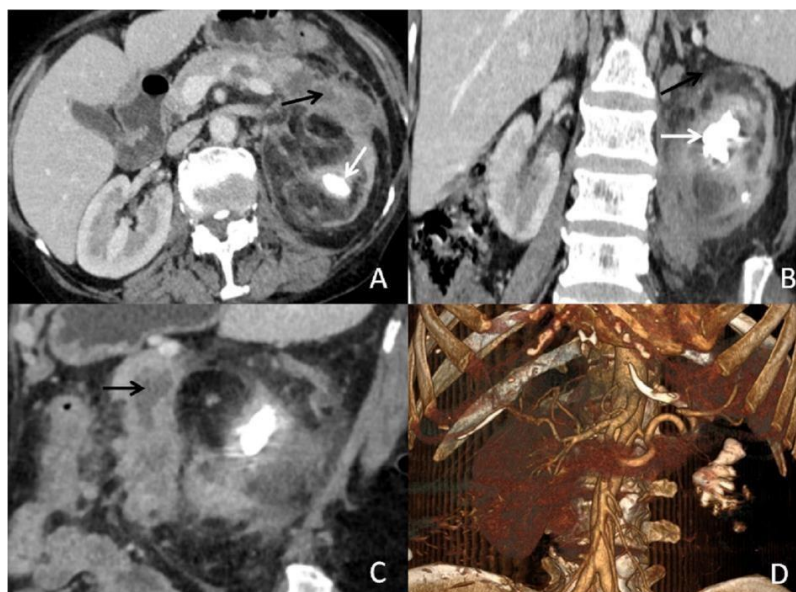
Contrast-enhanced abdomen and pelvis CT scan, delayed phase: (A) Axial image demonstrate a staghorn calculus in the left renal pelvis (white arrow) and peripherally enhancing hypodense collection in the perinephric region extending to the pancreatic tail (black arrow) and splenic flexure of colon. (B) Coronal reformatted image demonstrates enlarged left kidney with calculus in the renal pelvis (white arrow) and perinephric fat standing (black arrow). (C) Sagittal reformatted images showing multiple peripherally enhancing collection pockets suggestive of necrosis or abscess (black arrow), and (D) Arterial phase, 3D Volume rendering technique image, coronal plane shows non-visualisation of the intrarenal capillary network and abrupt cut off of the left renal artery at hilum along with a staghorn calculus.
